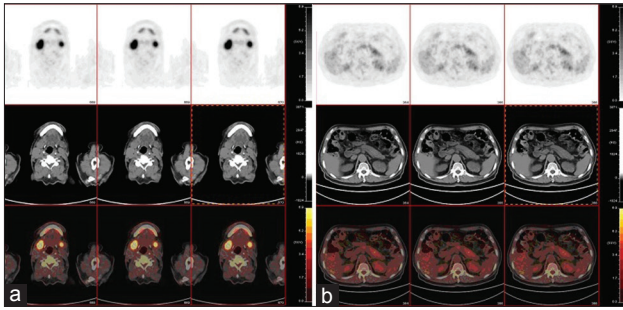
Positron emission tomography and computed tomography (PET-CT) images. (a) Abnormal 18-fluorodeoxyglucose uptake in bilateral submandibular glands and parotid glands. The maximum standardized uptake value (SUV) of the submandibular glands was 11.16, and of the parotid glands was 10.86; (b) The tail of the pancreas was mildly swollen. The maximum SUV was about 4.48, and about 5.06 after a delayed scan.
